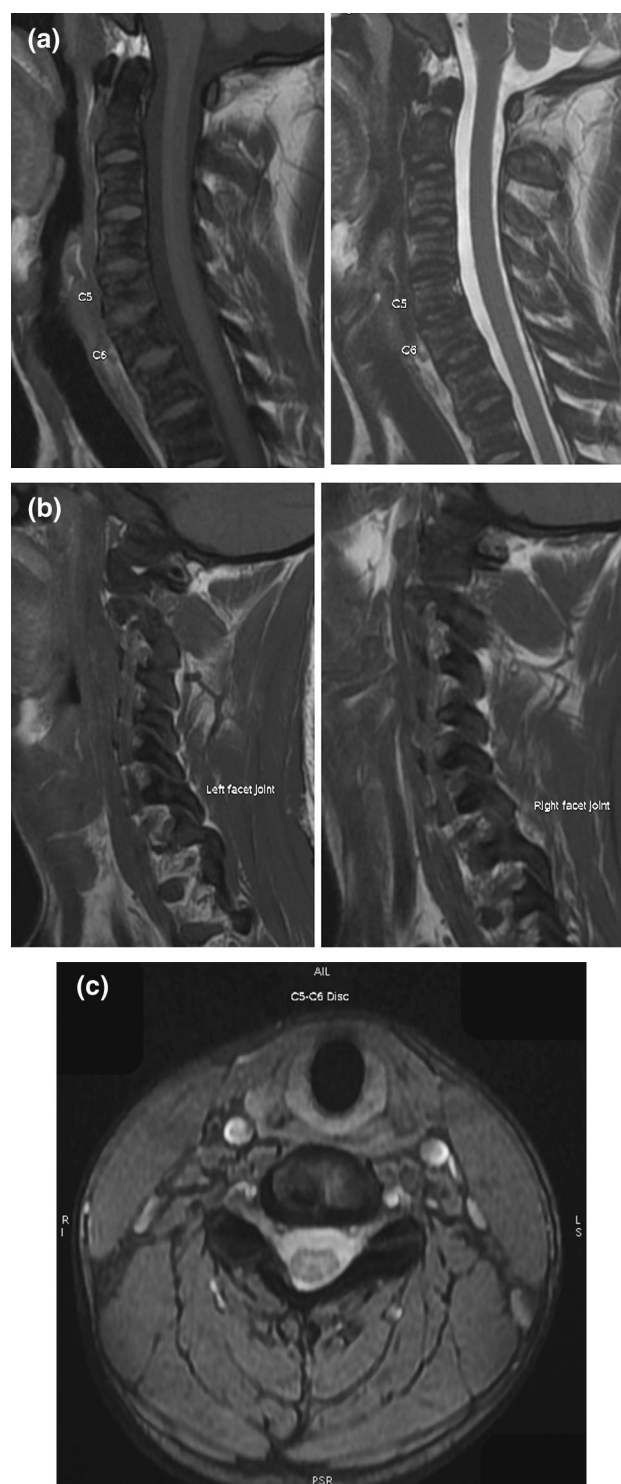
Follow-up MRI at 2.5 years after injury a T1 and T2 sagittal views, b left and right facet joints, c axial view at the level of C5–C6 intervertebral disc
